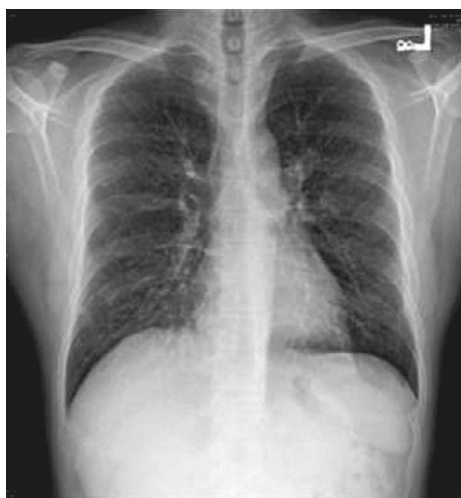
Chest radiograph shows reticular infiltration of bilateral lungs.
